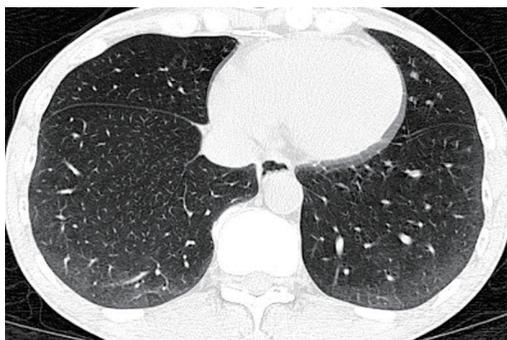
Axial high-resolution computed tomography (HRCT) image in a 56-year-old man with dcSSc reveals bilateral subpleural ground glass (GG) opacities in basal lungs, compatible with early nonspecific interstitial pneumonitis (NSIP) pattern.
